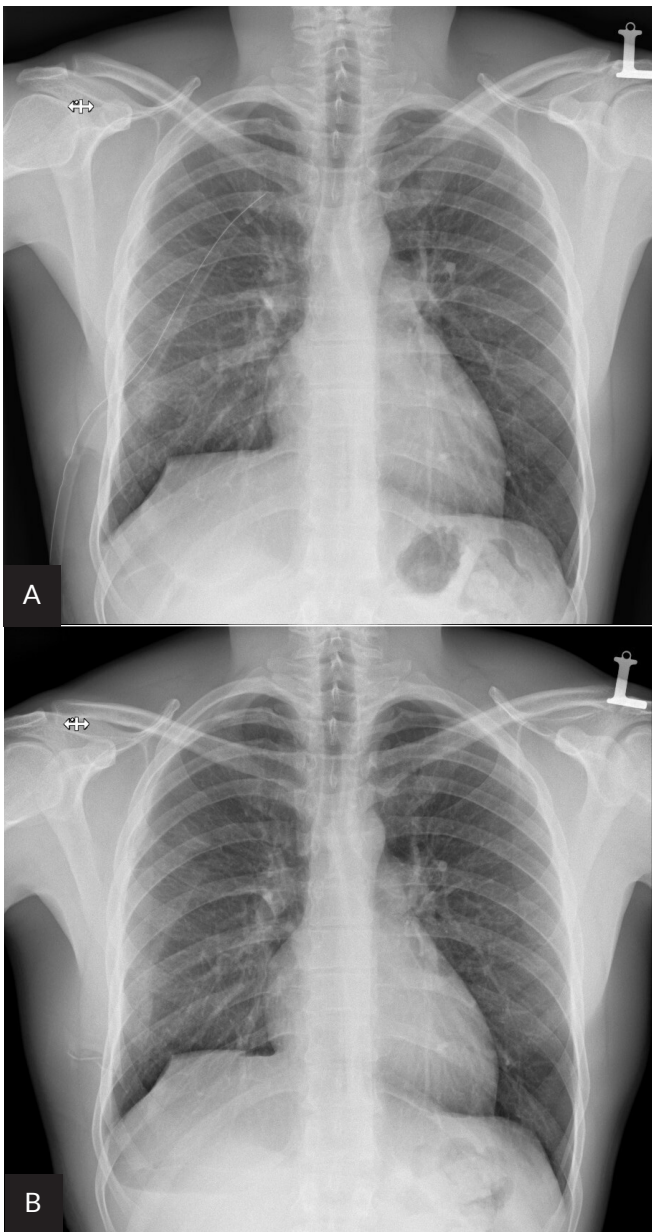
Case 9. X-ray. A. After drain. B. At discharge
